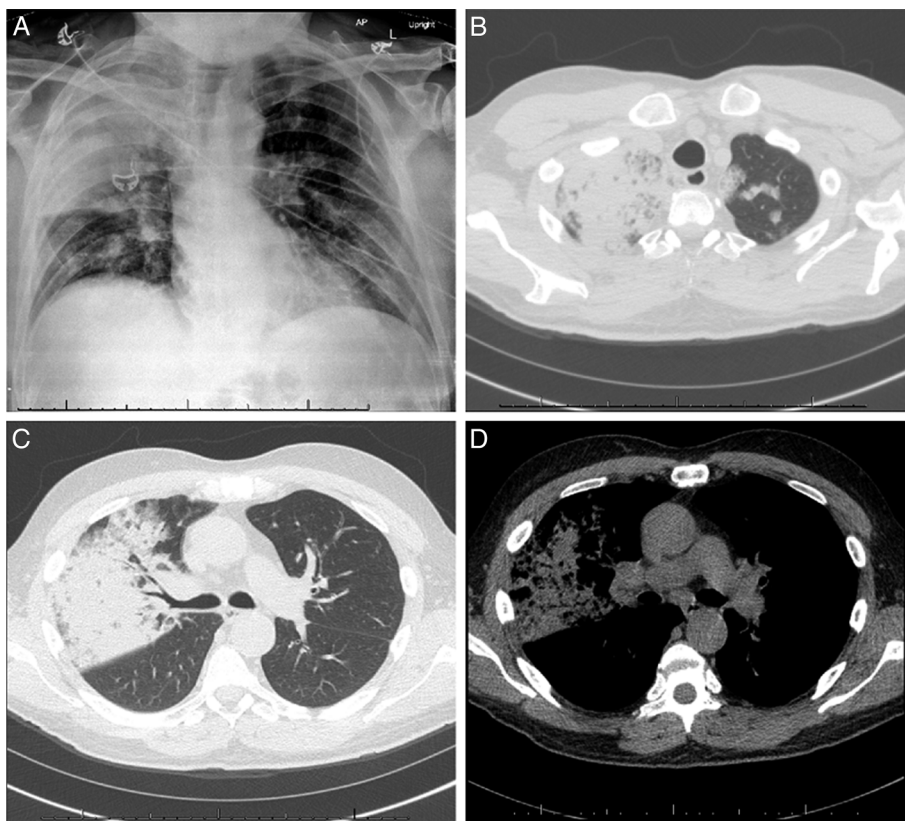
Thoracic imaging. A, Chest radiograph showing consolidation of the right upper lobe. B-D, Chest CT scan revealed right upper lobe consolidation, less extensive focal disease in the left upper lobe, and mediastinal lymphadenopathy in lung (B, C) and soft tissue (D) windows.
